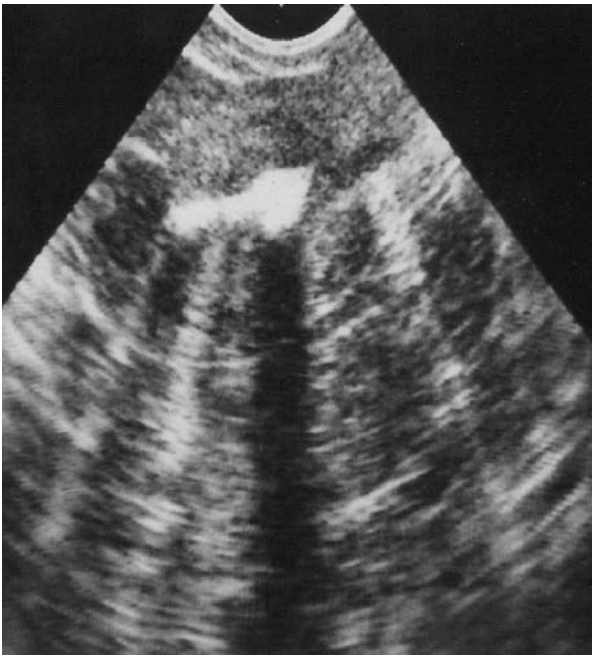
Transvaginal sonogram (*coronal view*) showing the same retained bony fragments that cause an acoustic back scatter
